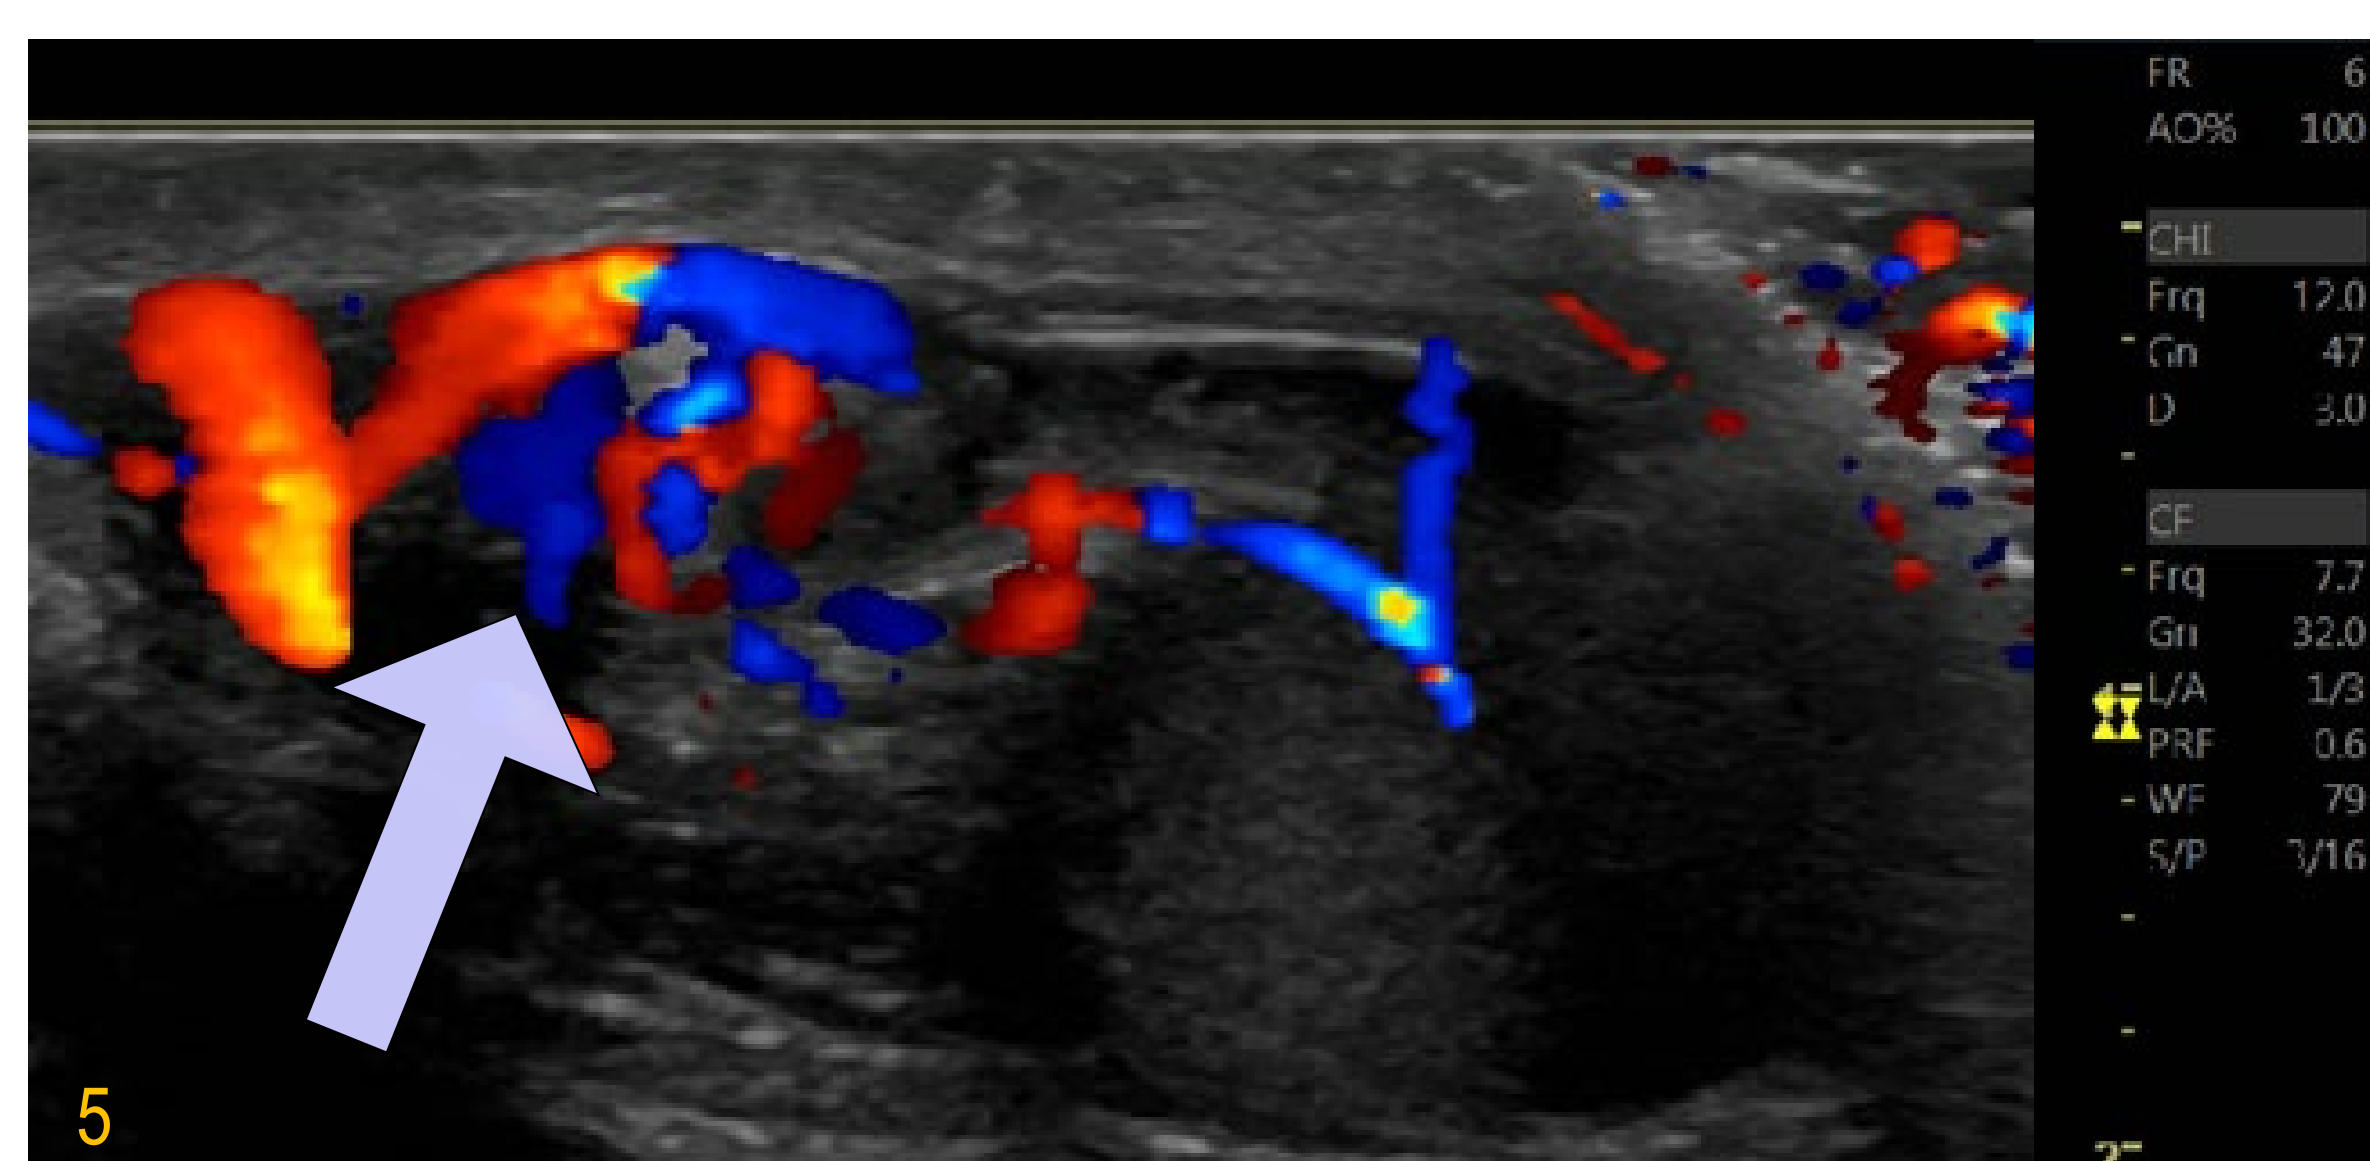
Colour Doppler image depicting the classic “Whirlpool sign” in a patient with intermittent torsion.
